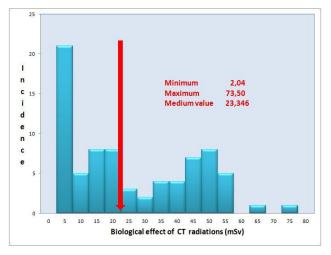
Cumulative radiation dose in CT
